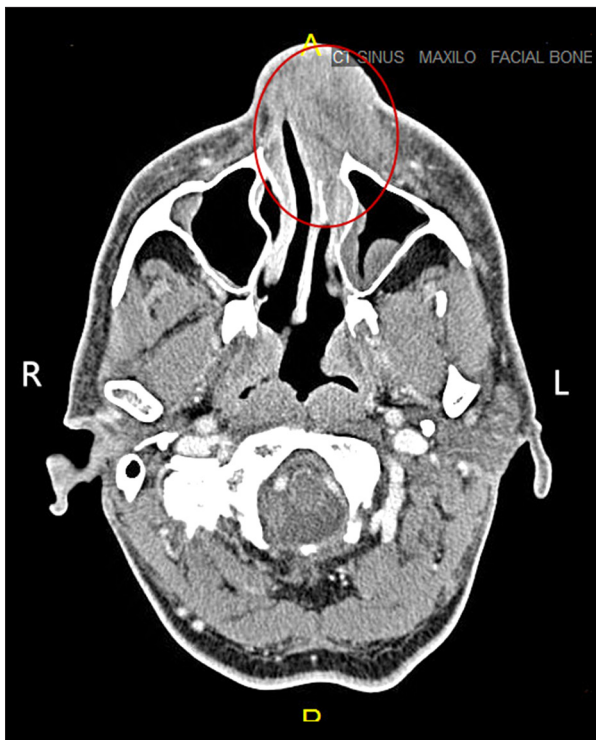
CT sinuses with IV contrast: a soft-tissue shadow in the left nasolabial fold with mucosal thickening in the maxillary and ethmoid sinuses.
